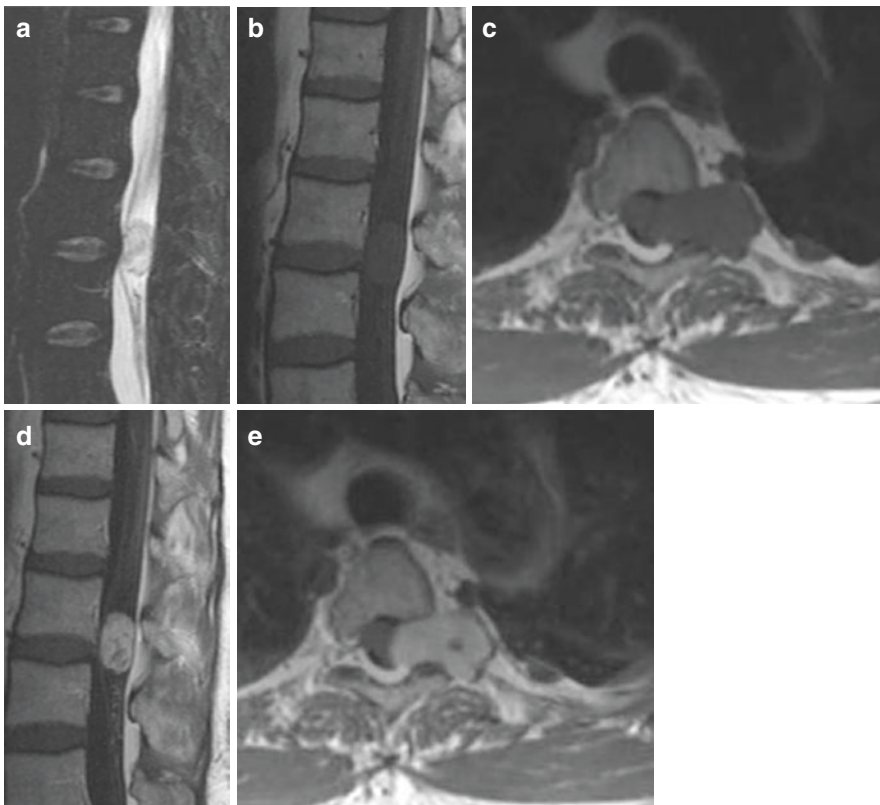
Schwannoma. Sagittal STIR (a), T1-weighted (b), axial T1-weighted (c), sagittal and axial contrast enhanced T1-weighted (d, e) images showing well-defined mass in spinal canal compressing the spinal cord with “dumbbell” shape, extending through neural foramen left side. Intense homogeneous enhancement of the mass is seen
